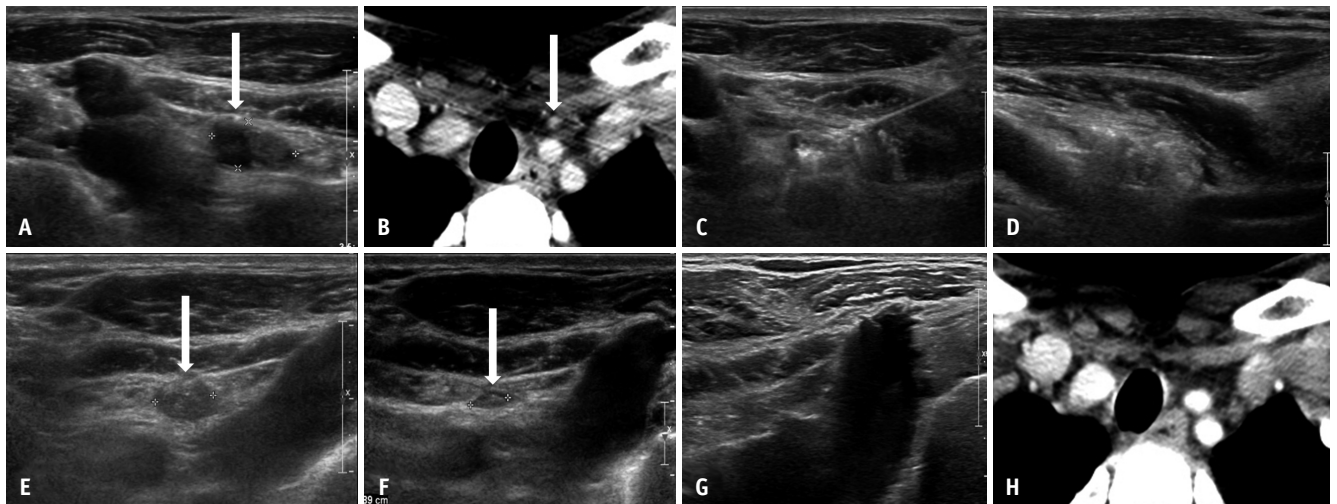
A 39-year-old male with recurrent papillary thyroid cancer at left supraclavicular area after thyroidectomy and radioactive iodine therapy. A, B: Transverse US image, a 1.2-cm-sized heterogeneous echoic metastatic lymph node in the left supraclavicular area (arrow, A). The lymph nodes show strong enhancement on arterial-phase contrast-enhanced CT (arrow, B). C, D: An internally cooled electrode with a 0.5-cm-sized active tip is inserted into the metastatic lymph node (C). After completion of RFA, the hyperechoic ablated zone is larger than the initial tumor size (D). E, F: One and seven months after RFA, transverse US scans show that the treated tumor gradually decreased in size (arrows). G, H: At 126 months after RFA, the treated tumor was not observed on US or CT. US = ultrasound, RFA = radiofrequency ablation
